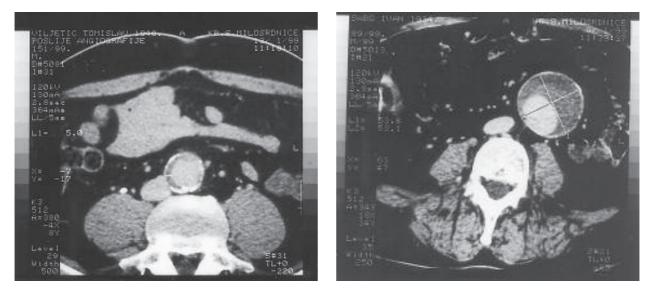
Angiography and CT scans of patient 2: saccular aneurysm with largest diameter of 6 cm.
